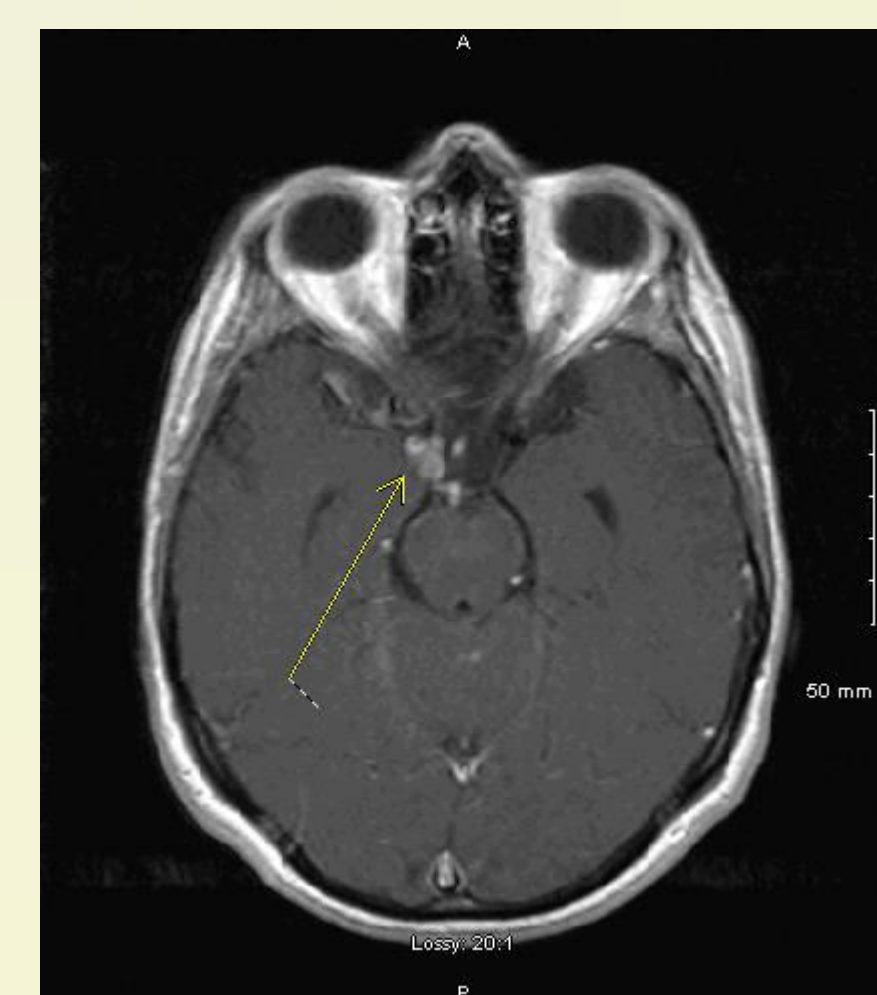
MRI T1 Axial + GAD showing suprasellar enhancing lesion. 2014
